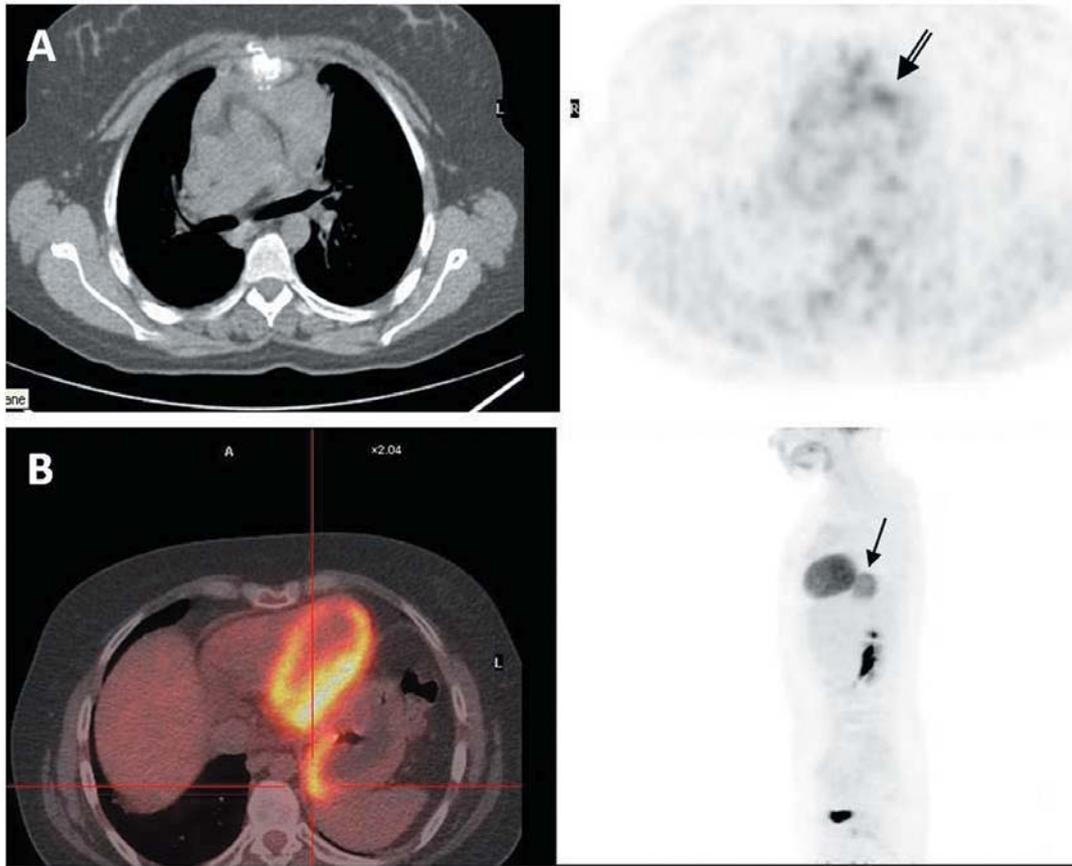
A: Post-treatment PET/CT images indicating mild but persisting ¹⁸F-FDG uptake ($SUV_{max} 5$) higher than that of the mediastinal blood pool in the mediastinal mass (open arrow). B: Post radiation PET/CT (fused and MIP images) indicating normal ¹⁸F-FDG uptake in the mediastinal mass but increased uptake in the stomach (black and white arrows).
